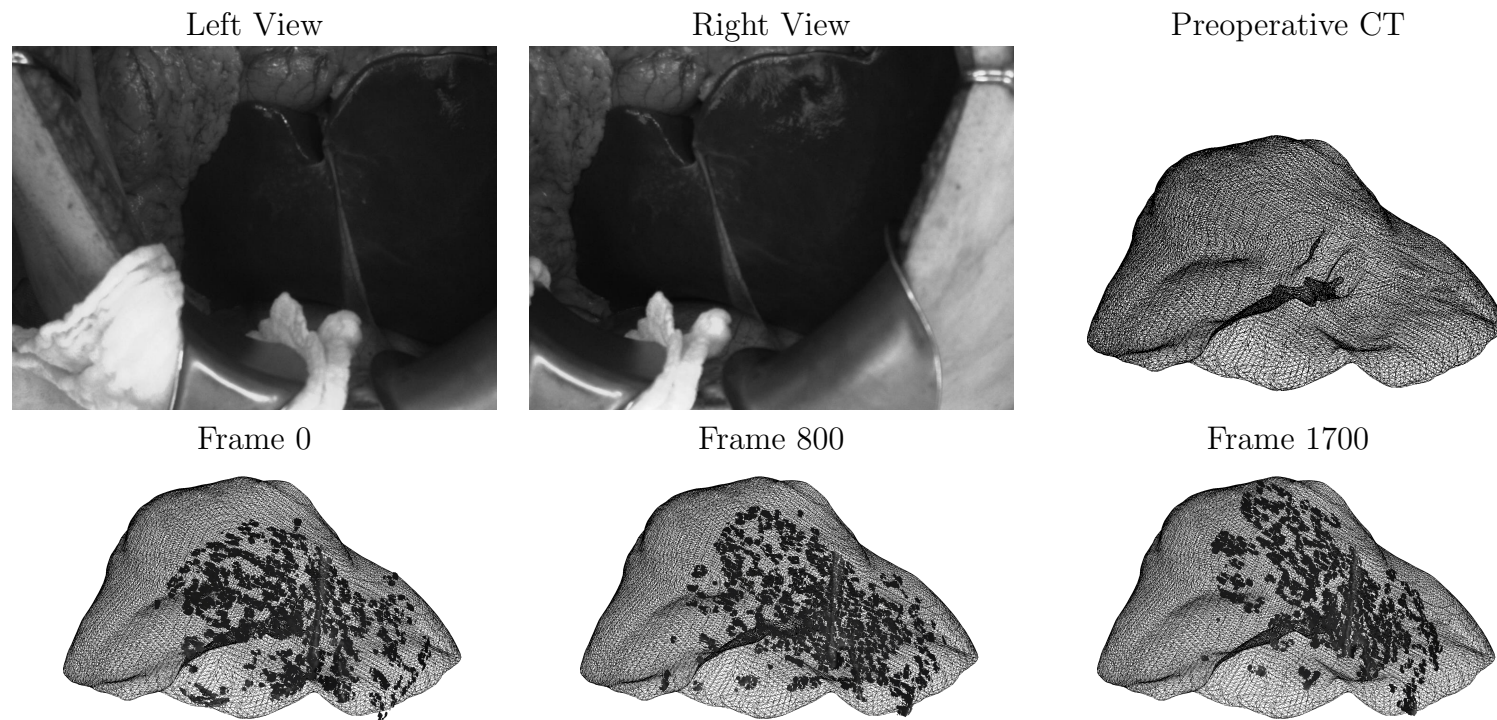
Qualitative Surface Registration Error (SRE) Results - Intraoperative Case 3. The left and right (non-rectified) views from the stereo camera are shown at the initial frame (frame 0). The preoperative *CT* scan is shown with the anterior face of the liver facing the camera. The recovered stereo reconstructions (shown in darkest grey), registered to the preoperative *CT* scan, are shown at frames 0, 800, and 1700.
